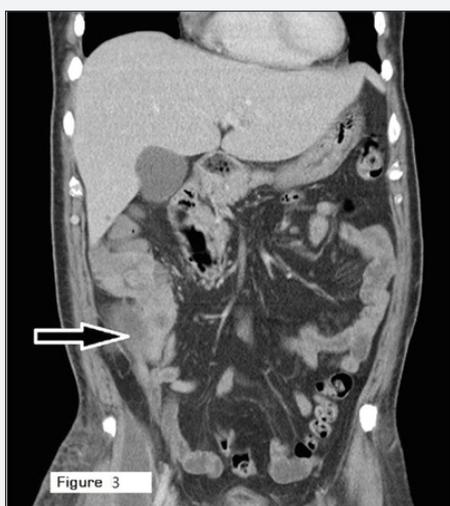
Contrast-enhanced CT scan of the abdomen showed cecal tumor with abscess formation involving right retroperitoneum and psoas muscle.
